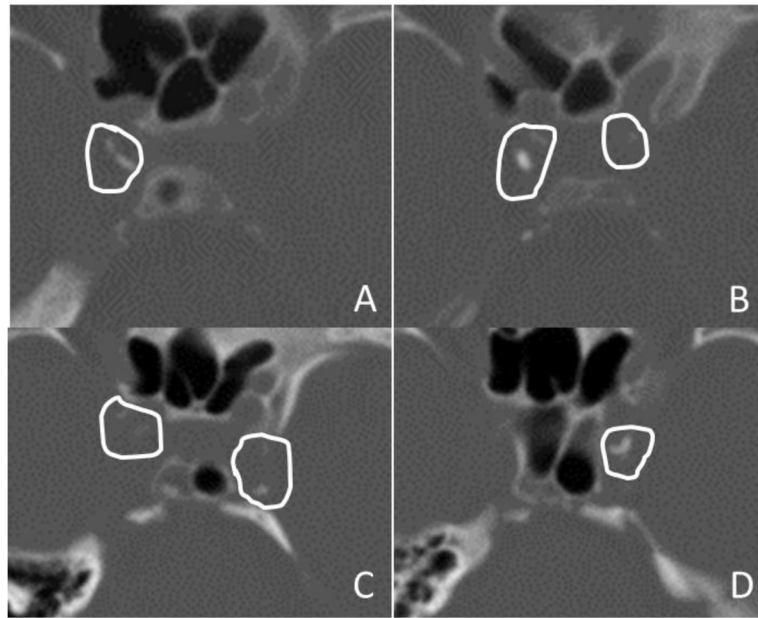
Representative Computed Tomography Images
